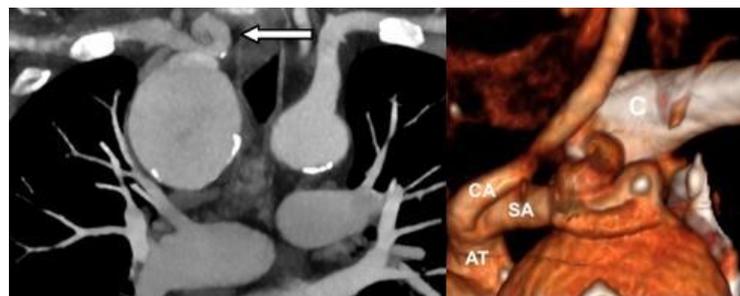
1B: CT angiogram showing the severe tortuosity of the distal subclavian artery (arrow)1A. multiplanar reconstruction of the SAA, 1B: postero-lateral view, 3D reconstruction. C=clavicle; SA=subclavian artery; CA=carotid artery; AT=anonymus trunk
